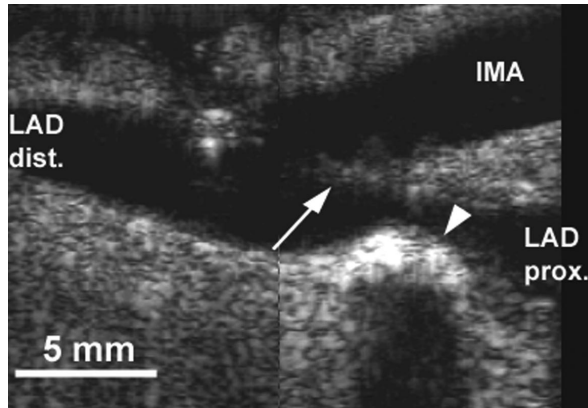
Purse string anastomosis: panels from left to right, transverse and longitudinal ultrasound image, angiogram and cast. Note in the transverse ultrasound image the severe narrowing of the anastomotic orifice (arrow) and the small resulting lumen (arrowhead). IMA, internal mammary artery; LAD, left anterior descending coronary artery; Prox, proximal; Dist, distal.
